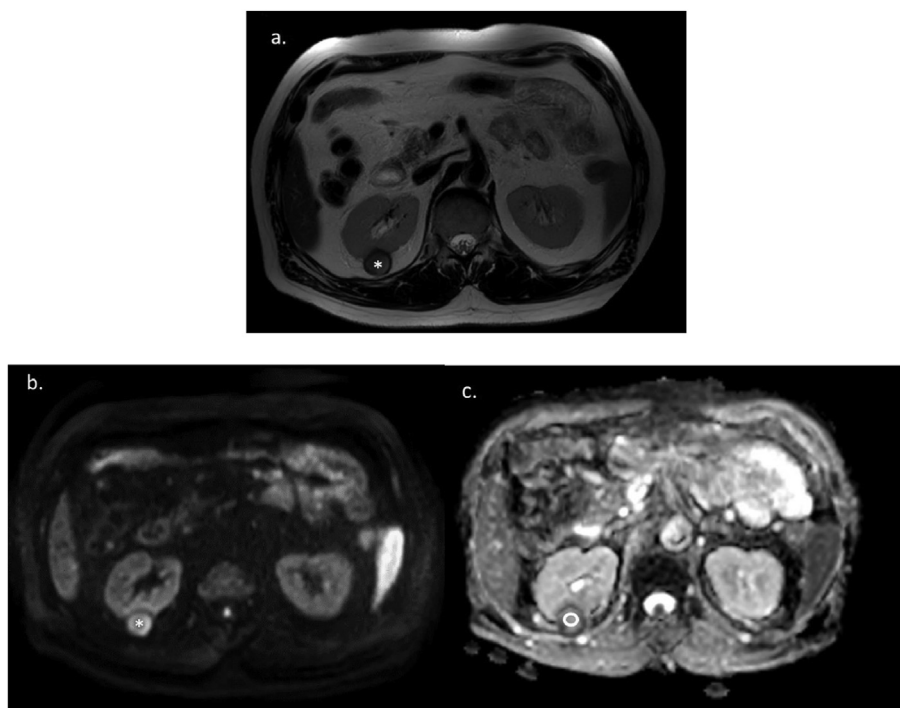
Renal cell carcinoma post cryotherapy ablation, a. * identification of lesion on T2W image, b. * lesion on DWI b800, c. ROI identified in centre of lesion on ADC.
